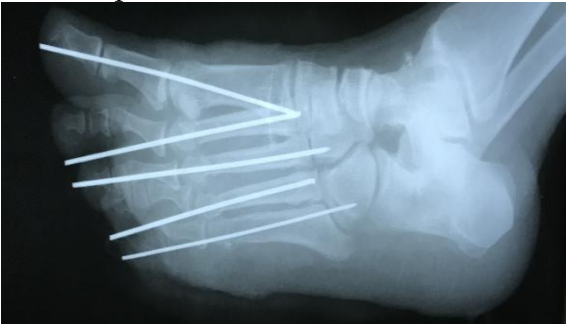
Six weeks post-operative X-ray
